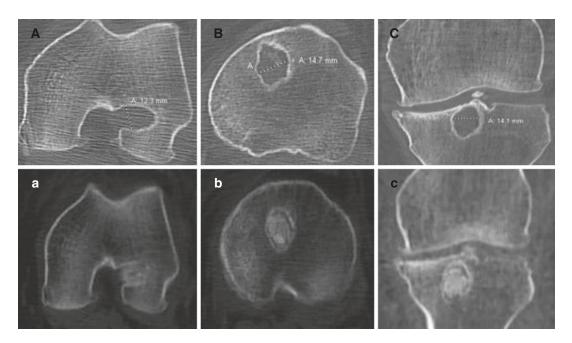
(A) Axial CT (femur) (B) Axial CT (tibia) (C) Coronal CT pre-bone grafting. (a) Axial CT (femur) (b) Axial CT (tibia) (c) Coronal CT post-bone grafting
